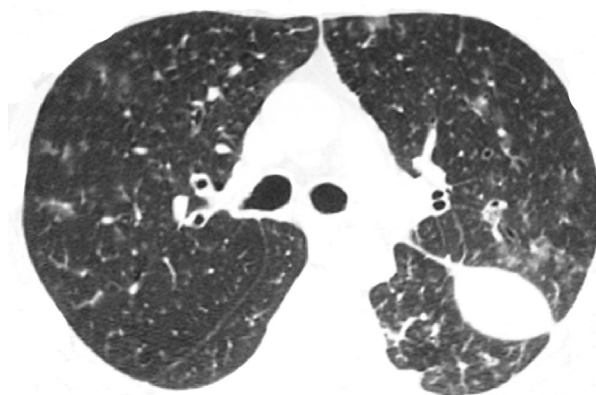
A 52-year-old woman with heart failure and a pleural pseudotumor. Axial computed tomography image (lung window settings) obtained at the level of bronchial bifurcation shows a sharply circumscribed, homogeneous opacity in the left hemithorax. The opacity is elliptical; with tapering ends situated in keeping with the position of the major fissure. The pseudotumor disappeared completely after 2 weeks of appropriate therapy.
